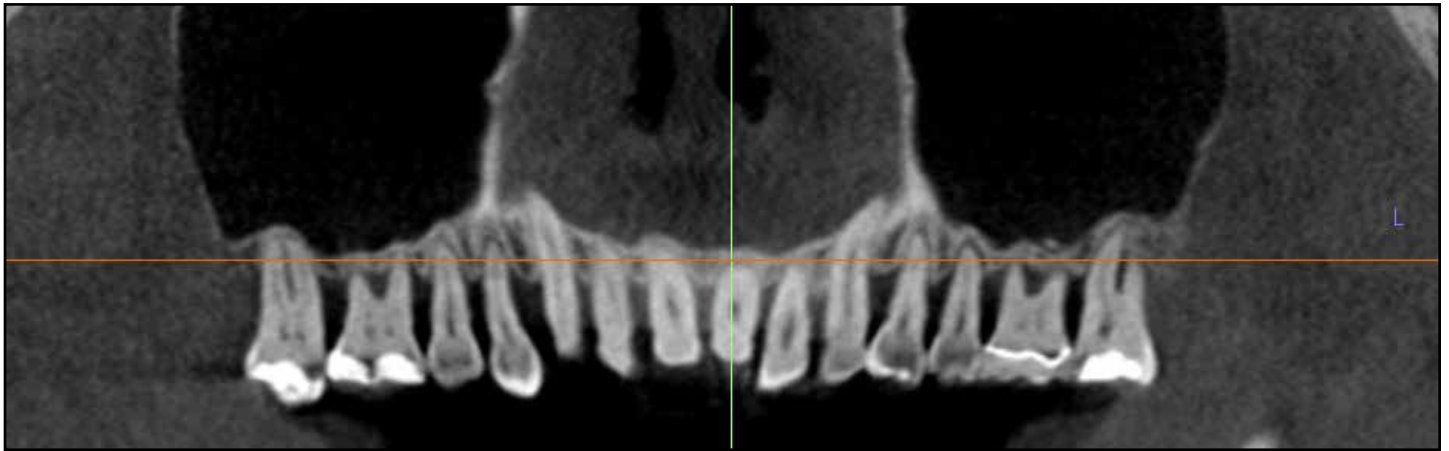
Presurgical CBCT scan prior to maxillary sinus augmentations (coronal view).
